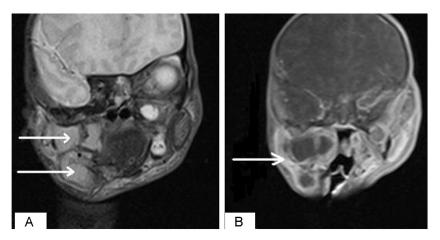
MRI shows large multiloculated mass spreading to lateral pharyngeal recess (A) and peripherally enhancing after intravenous Gadovist infusion (B).
